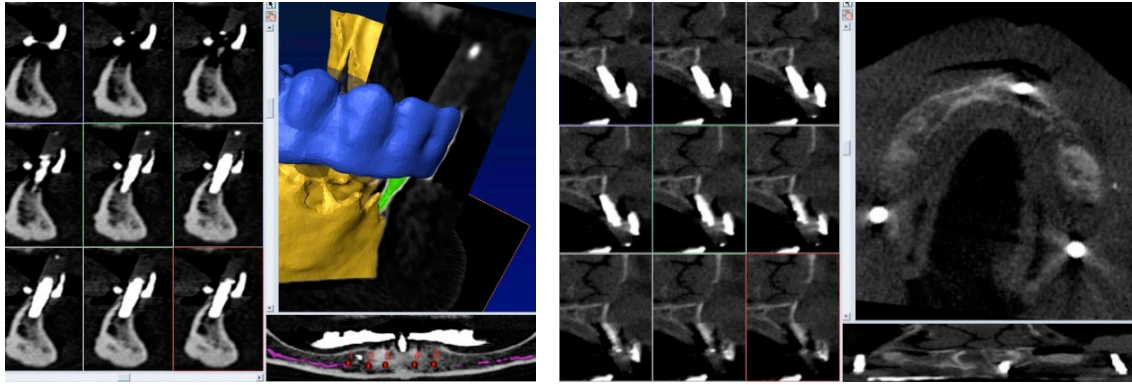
the determination of the reference points on the CT using implant placement-planning software.
